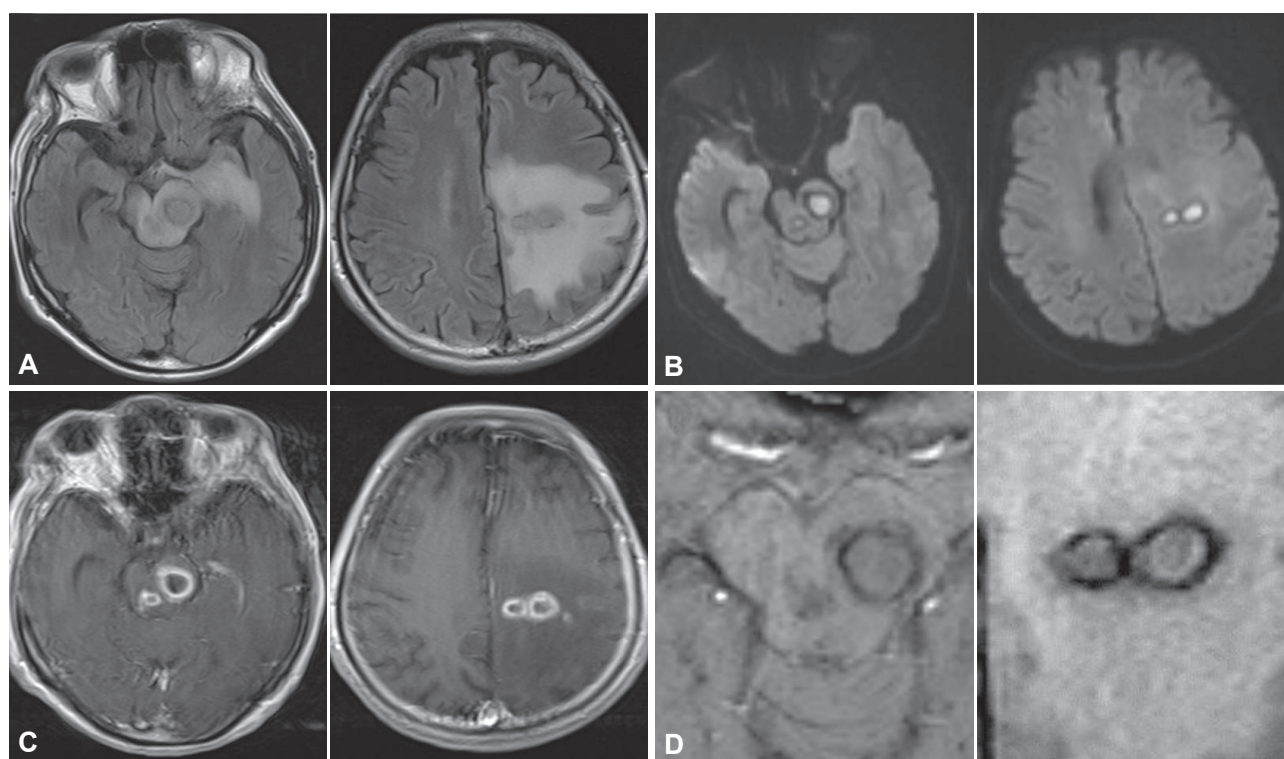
Brain magnetic resonance imaging on admission. A: Fluid-attenuated inversion-recovery images disclosed iso- to hypointensity lesions in the midbrain and left cerebral hemisphere with surrounding edema. B: T1-weighted images with gadolinium enhancement showed ring enhancement in these lesions. C: High-intensity signals were present inside in the lesions in diffusion-weighted imaging. D: Susceptibility-weighted imaging revealed a dual rim sign: defined as two concentric rims at the lesion margins, with the outer rim being hypointense and the inner rim hyperintense relative to the cavity contents.
